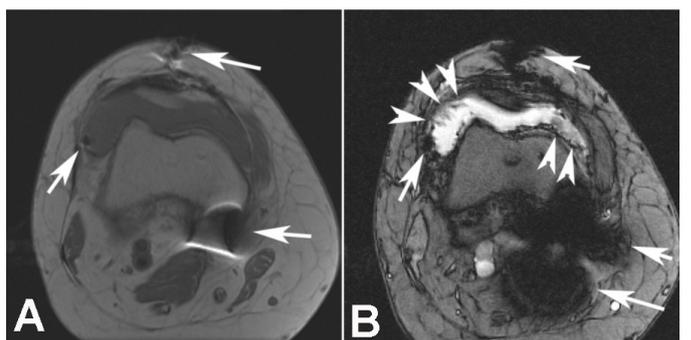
Postoperative axial T1-weighted spin-echo (A) and gradient echo (B) MR images of the right knee. (A) Multiple metal artifacts are seen on the T1-weighted spin-echo image (white arrows). (B) Gradient-echo image on the same slice position as (A) revealed villous shaped synovial proliferation in the expanded joint space. Mild blooming artifact was seen in the synovium (arrowheads). Metal artifacts (white arrows) are stronger on gradient-echo image than on T1-weighted image. These imaging findings in addition to bloody aspiration were compatible with pigmented villonodular synovitis.
